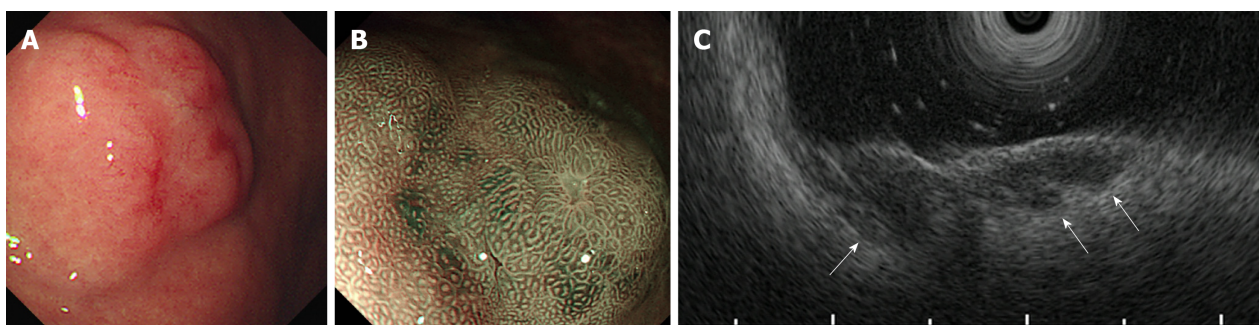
Endoscopic and ultrasonographic images of gastric carcinoma with lymphoid stroma (Case 1). A: A protruding lesion with central depression is covered with mucosa, the surface of which shows slight hyperemia; B: Magnifying narrow-band imaging reveals regular round and oval pits on the surface of the tumor; C: A 7.5-MHz endoscopic ultrasound image shows hypo-echoic lesions projecting into the third hyperechoic layer (white arrows).
